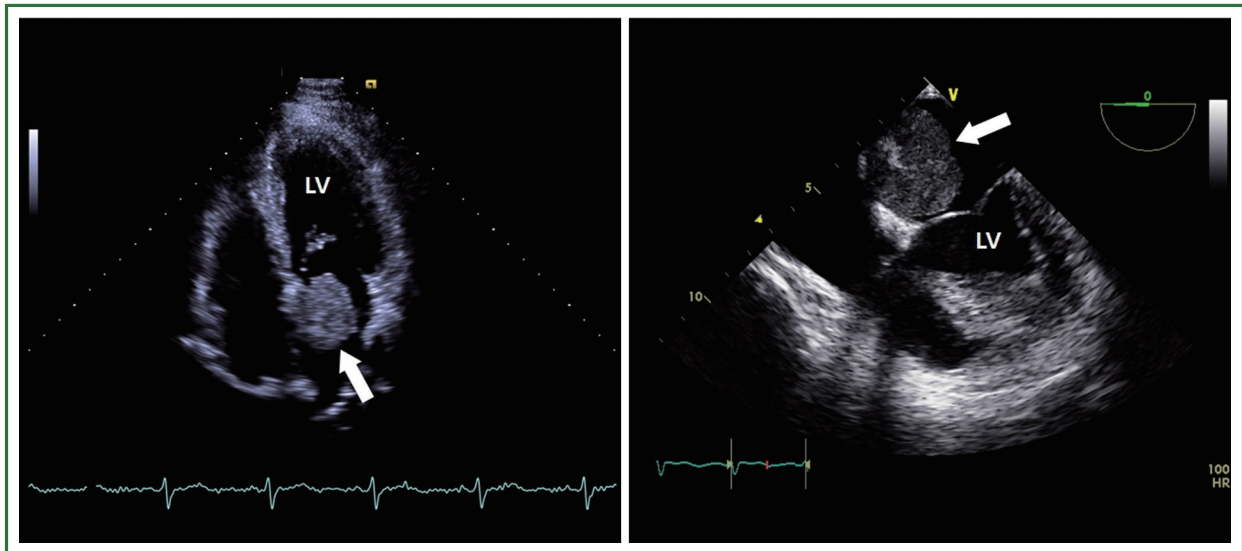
Echocardiographic image showed left atrial mass (arrows). Abbreviation: LV, left ventricle.
